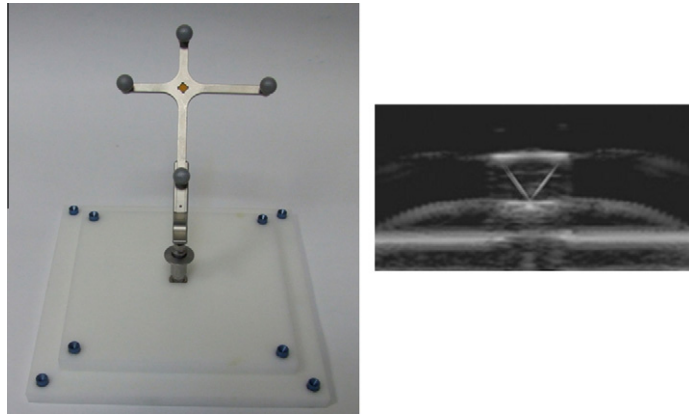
The calibration plate and the ultrasound scan of a metallic fovea.
